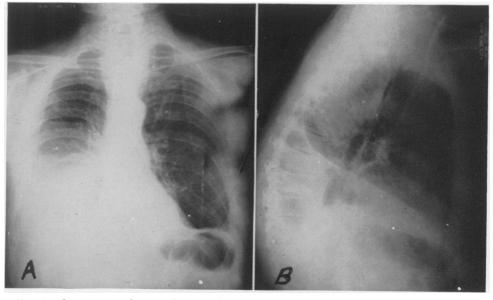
Chest x-rays taken on the second postoperative day demonstrating the appearance of fluid in the right pleural cavity.
